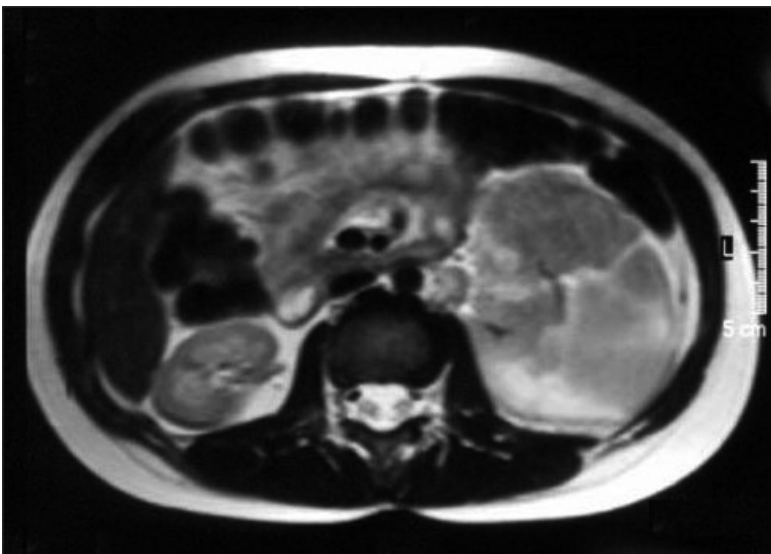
MRI scan of the abdomen of patient II showing leukemic infiltration of the left kidney 10 months after alloHSCT.
